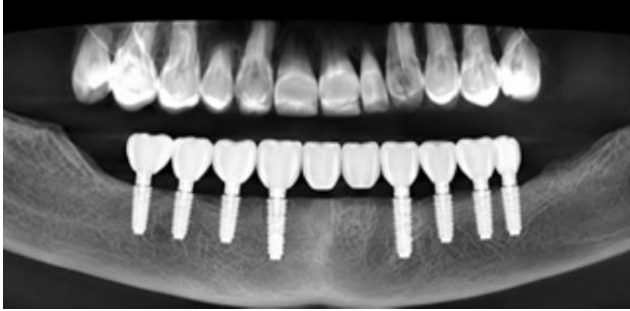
CBCT evaluation demonstrating A metal-ceramic fixed bridge supported by the 8 implants
